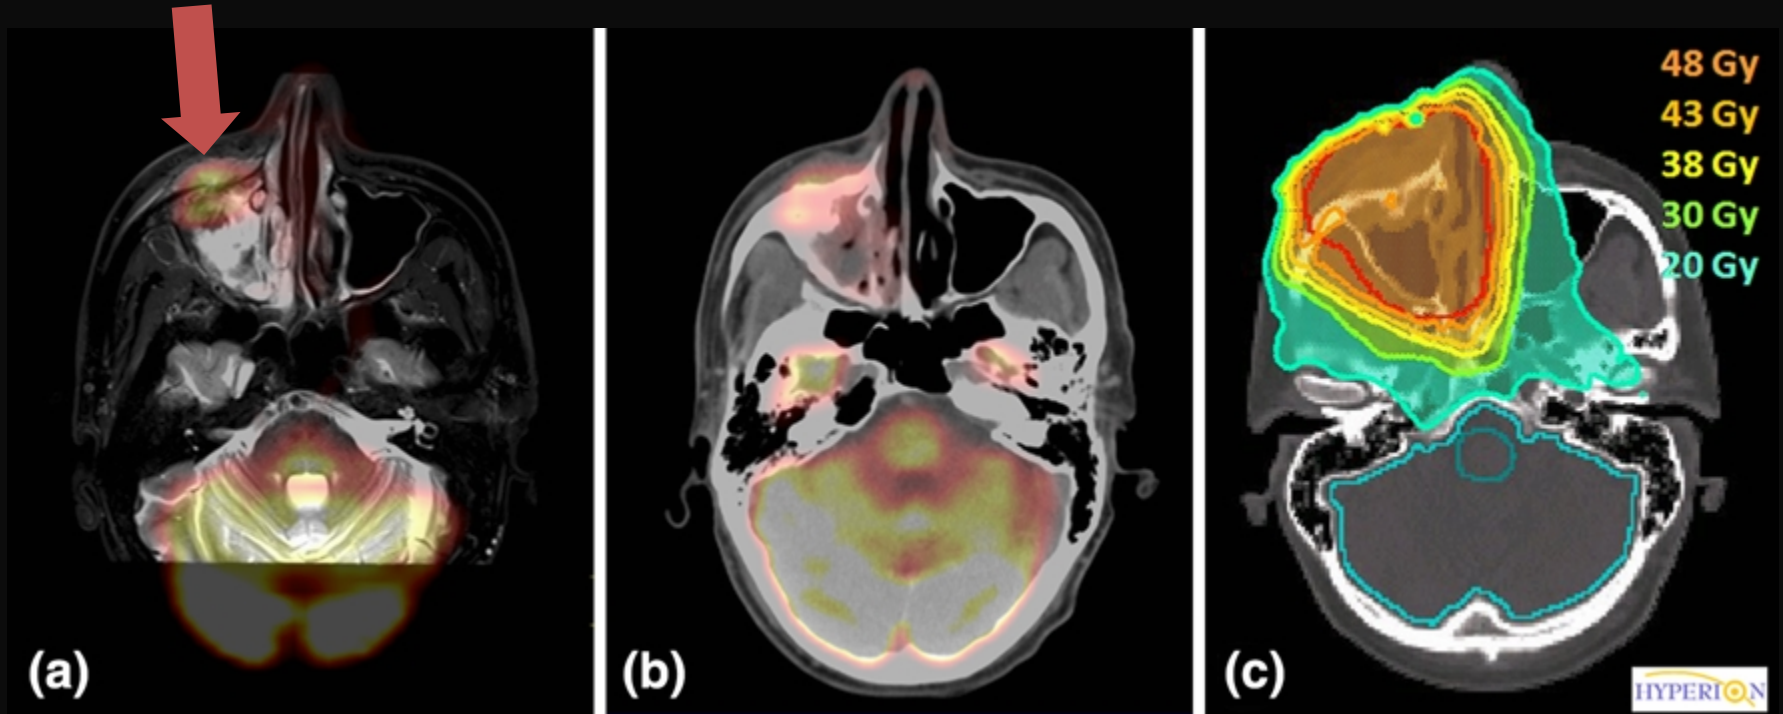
Simultaneous $[^{18}\text{F}]$ -FDG PET/MRI of a 41-year-old patient with sinus cancer (a) and corresponding PET/CT (b). GTV was contoured on both T2-STIR MRI and FDG PET data. IMRT plan with a total dose of 60 Gy to the PTV is shown in (c). Regions of interest: PTV (red), brain stem (dark green), brain (light blue).
